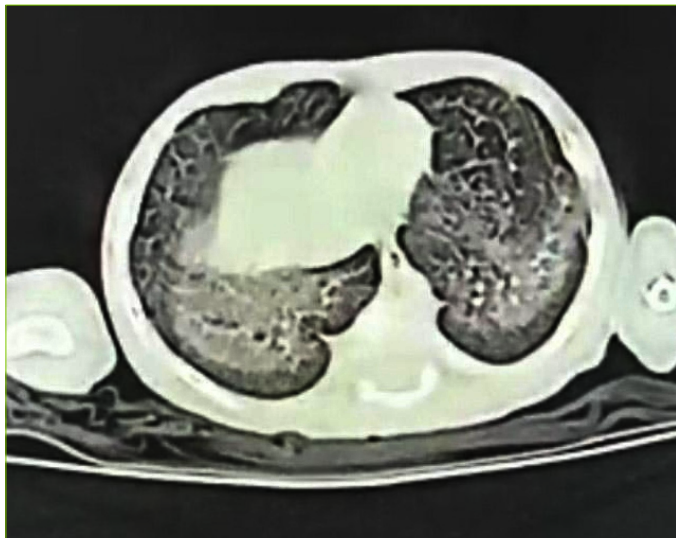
CT Thorax at diagnosis
